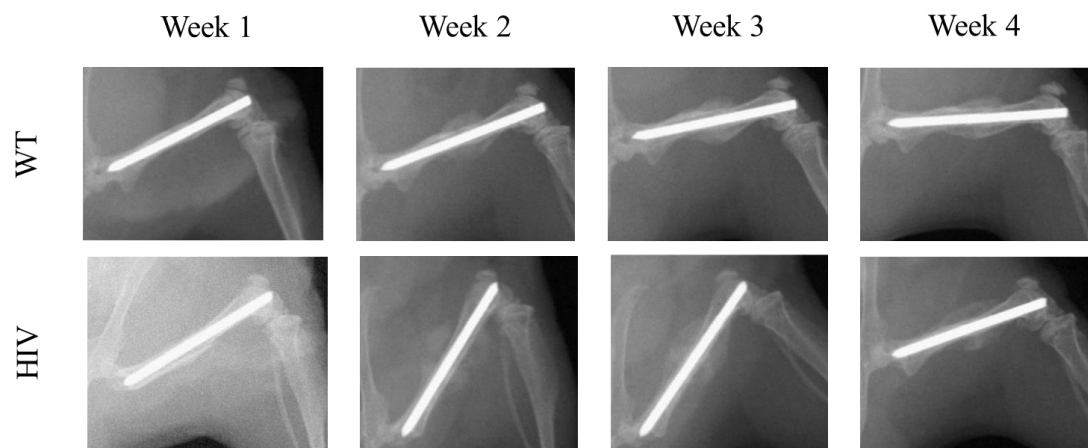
Representative 2-D radiographs of fracture healing
